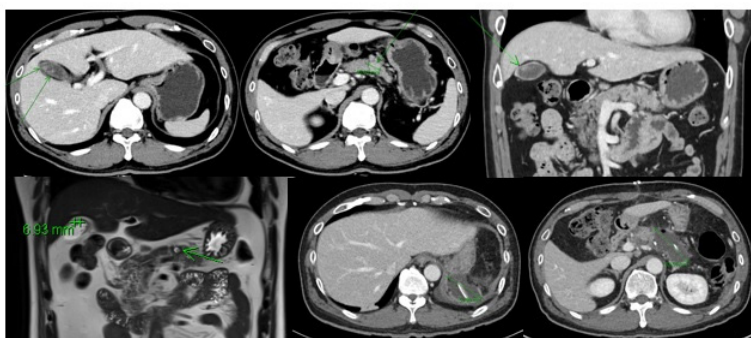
(A) Abdomen CT: Multiple GB polyps (B) 1. Small enhancing nodular lesion at the pancreas body (1.7cm) with mild acute pancreatitis in the upstream pancreas tail. (C) Intraluminal papillary growing enhancing lesions in the GB (D) Pancreas MRI: 1. Small thick peripheral enhancing lesion with central cystic component at the pancreas body (1.7cm). with acute pancreatitis, pancreas tail (E) Localized fluid collection at the distal pancreatectomy site and left subphrenic space
